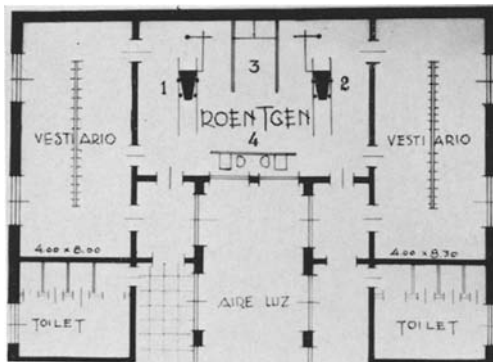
The Argentine Center of Thoracic Census with two roentgenphotographic apparatus "Manoel de Abreu," under Dr. Vaccarezza's direction, to be inaugurated in Buenos Aires, May, 1939. 1 and 2, apparatus; 3 and 4, x-ray protectors.
